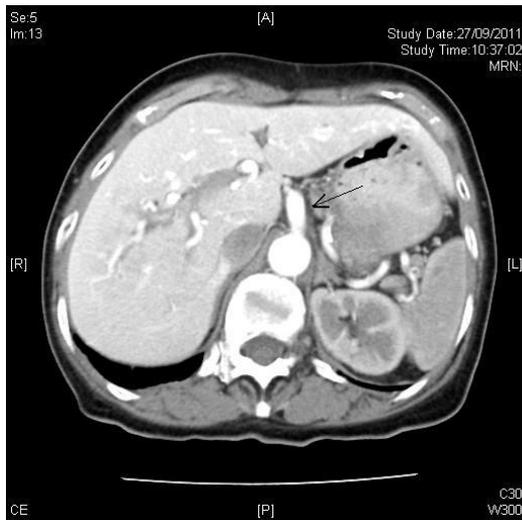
Contrast-enhanced CT of abdomen arterial phase images. Marked dilated common hepatic artery and intrahepatic branches.
